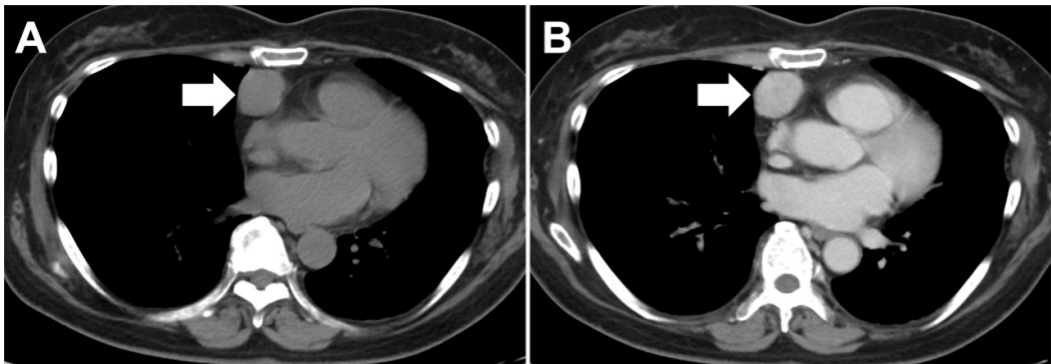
A female patient in her 50 s with thymoma (WHO type A) without MG. Axial (a) unenhanced CT and (b) contrast-enhanced CT showing higher tumor contrast enhancement (95.5 HU) (arrows).
